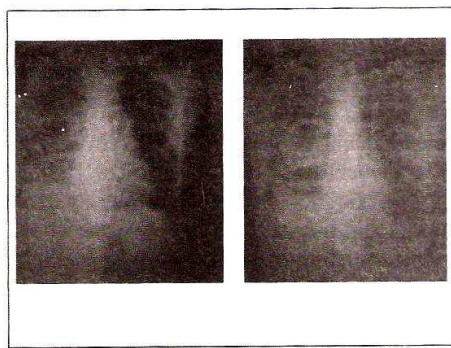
Comparison before and after treatment course of chest X-ray
